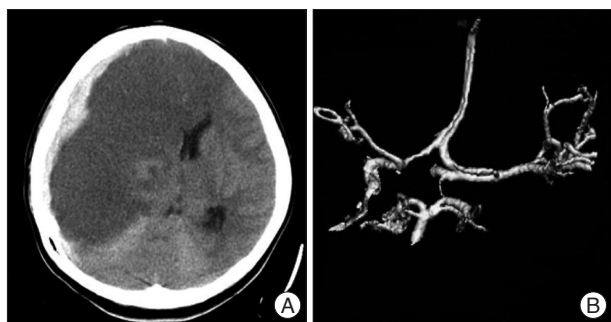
A : Computerized tomography (CT) showing an acute subdural hematoma with a multi-territory infarction including middle cerebral artery distribution (malignant post-traumatic cerebral infarction), B : CT angiography showing the vascular distortions of both anterior cerebral arteries and compression of the right middle cerebral artery (arrow) caused by a mass effect.
